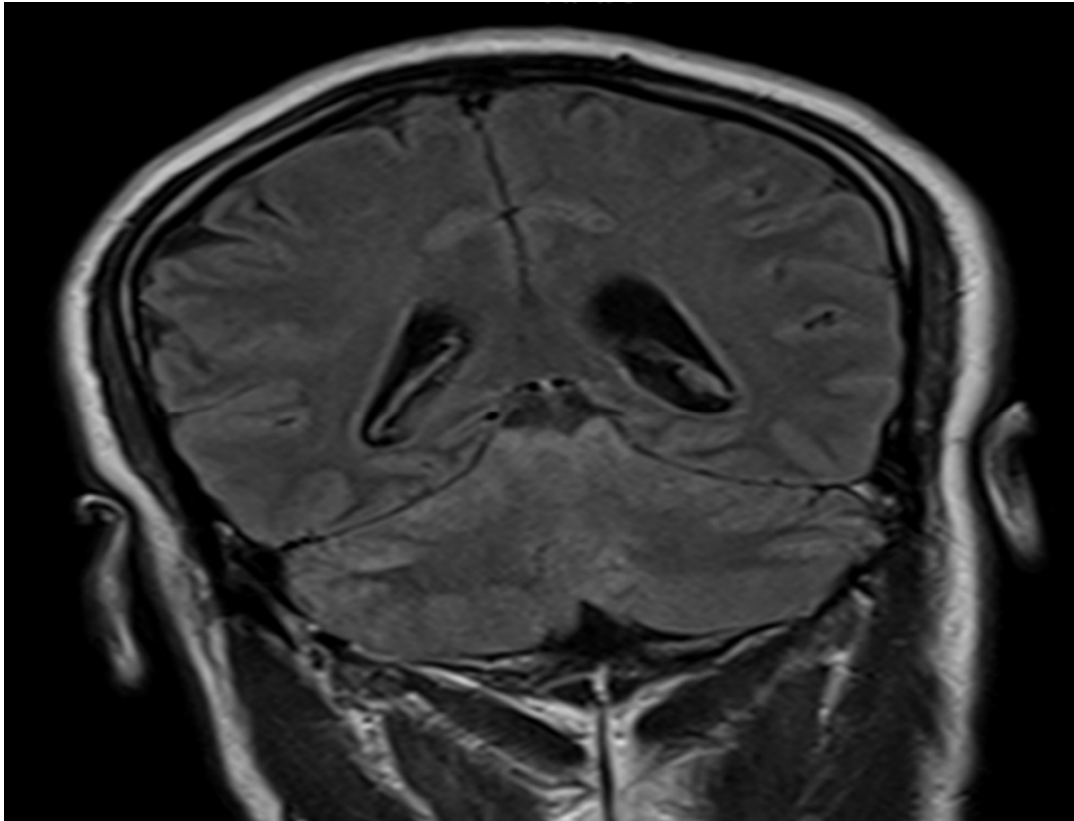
80 years old male admitted with diagnosis of meningitis. Unenhanced FLAIR shows hyperintense signals on FLAIR sequence with loss of CSF signals. Cerebrospinal fluid analysis shows high protein without any organism on culture and sensitivity. Subsequent cytology was positive for malignant cells
